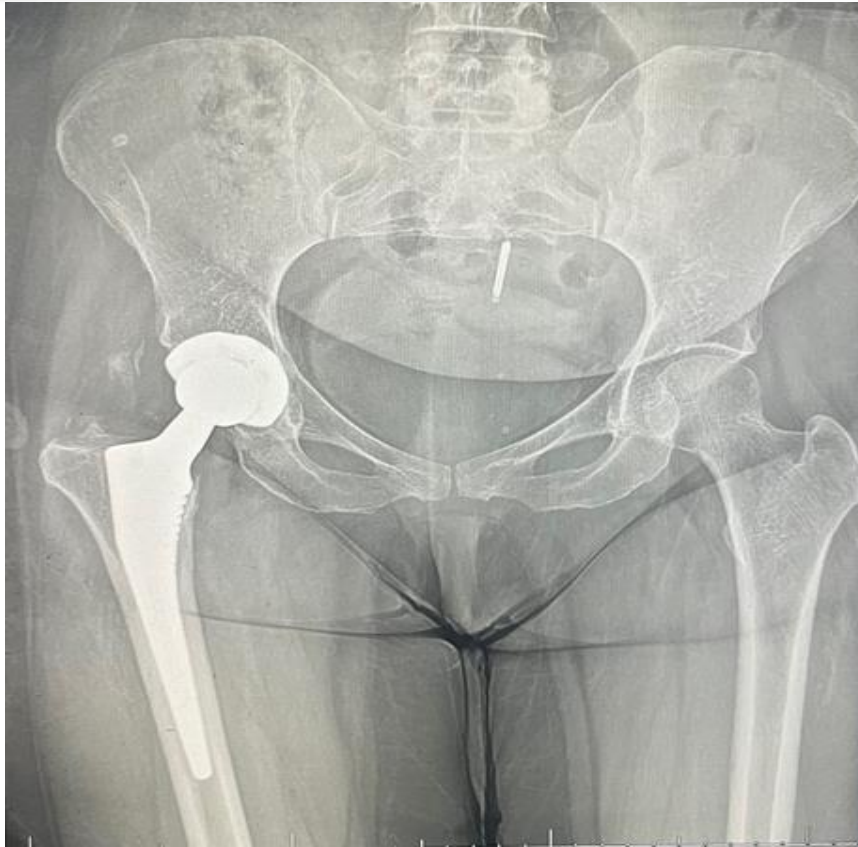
AP radiograph of the pelvis in one-year follow up
